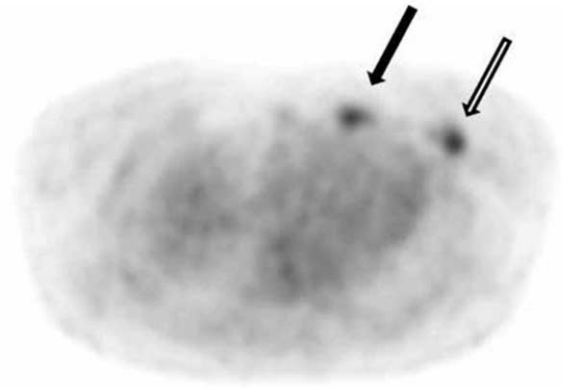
Axial image of PET scan shows increased FDG uptake foci in the Lt. anterior chest wall (black arrow, SUV = 2.4) and left breast (open arrow, SUV = 4.5).
